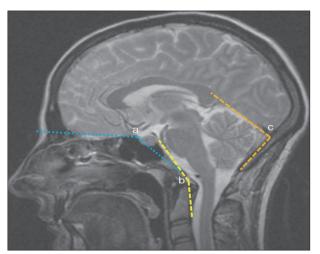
A MR imaging of Welcher basal angle (a), Wackenheim klivus angle (b) and Slope of Tentorium Cerebelli (c).
